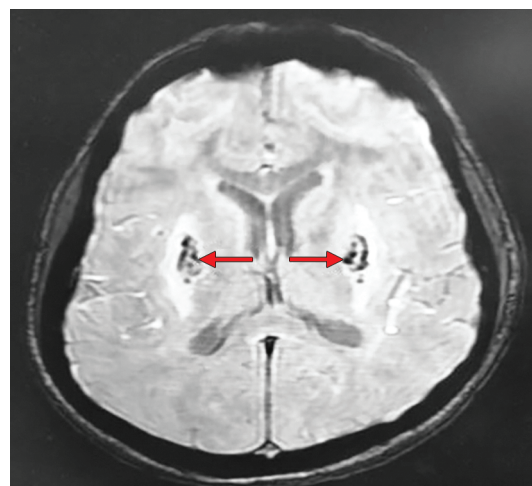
Susceptibility-weighted imaging (SWI) MRI showing hemorrhagic necrosis in bilateral putamina (red arrows)
